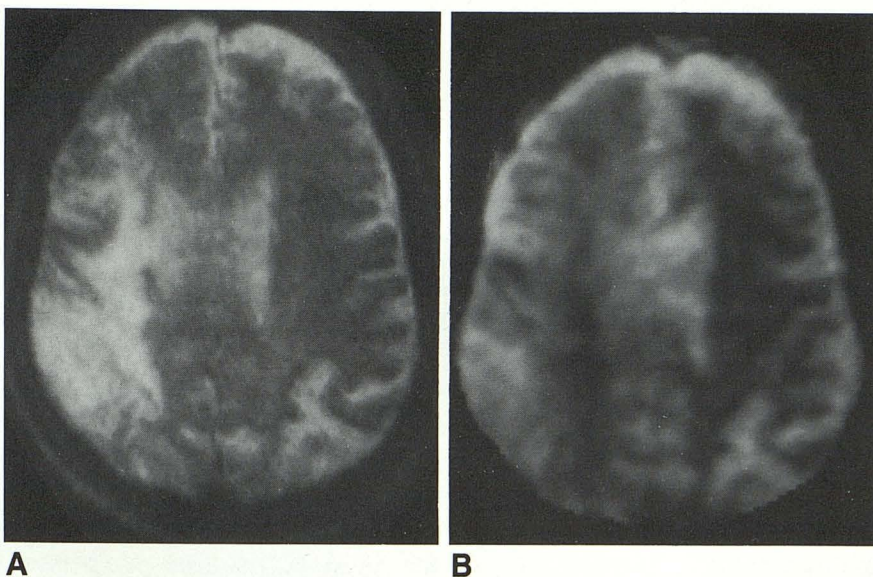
A 70-year-old patient with embolic infarction of the right middle cerebral artery was studied at 8 weeks after the ischemic attack. A comparison of the T2-weighted image (A) and the ADC map (B) shows that, within an infarct with uniform hyper-intensity in a conventional T2-weighted image, diffusion imaging reveals subregions with varying amounts of water diffusion. Certain subregions have increased diffusion, while others have decreased diffusion relative to normal brain tissue.
